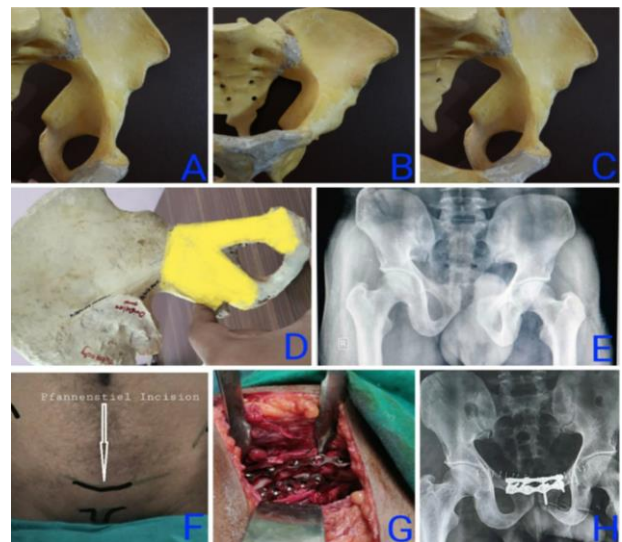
Pelviacetabular fracture managed with MSA; (A-D) Accessed regions of MSA, (E) preoperative X-ray, (F) landmarks for Pfannenstiel incision, (G) intraoperative photograph showing plate fixation, (H) postoperative X-ray.
